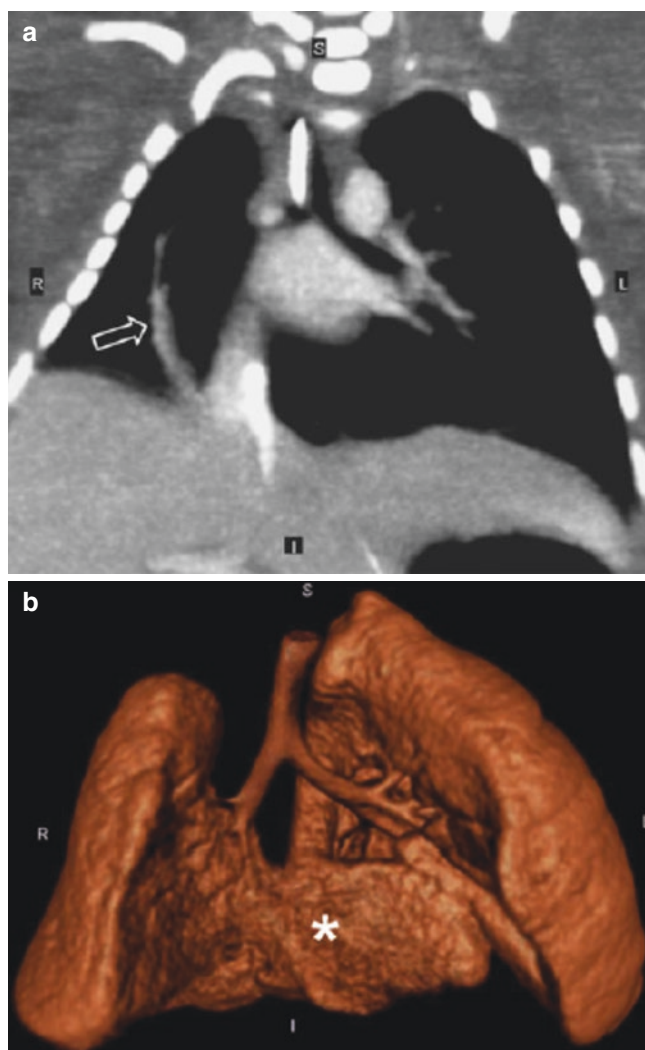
Hypogenetic lung syndrome (scimitar syndrome) with horseshoe lung in a young child. (a) Enhanced coronal CT image shows a scimitar vein (arrow) and hypoplastic right lung. (b) Anterior view of 3D volume-rendered image of the central airway and lungs demonstrates a horseshoe lung. Inferior medial portions (asterisk) of both lungs are fused. (Case courtesy of David Stringer, M.D. From Lee et al. [112])
